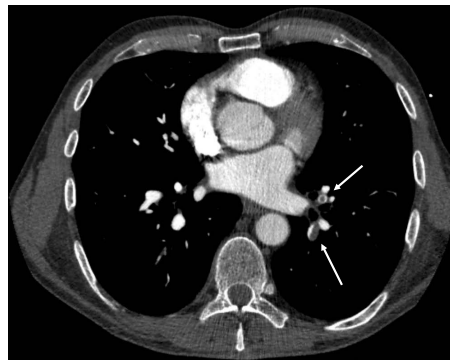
Computed tomography pulmonary angiography of patient with segmental pulmonary emboli in the left pulmonary artery.
